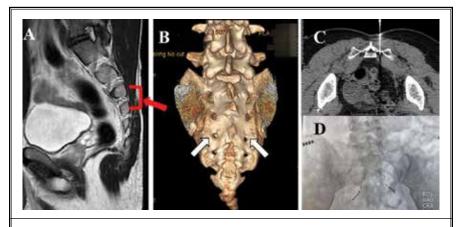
The surgical procedure of sacral nerve stimulation implantation. A Spinal cord MRI, sagittal T2-weighted sequence to identify the position of sacral nerve. B and C CT shows that the electrode puncture needle is inserted into the third posterior foramen. D X-ray shows that the electrodes are located on both sides of the sacral nerves. MRI: magnetic resonance imaging; CT: computed tomography.
